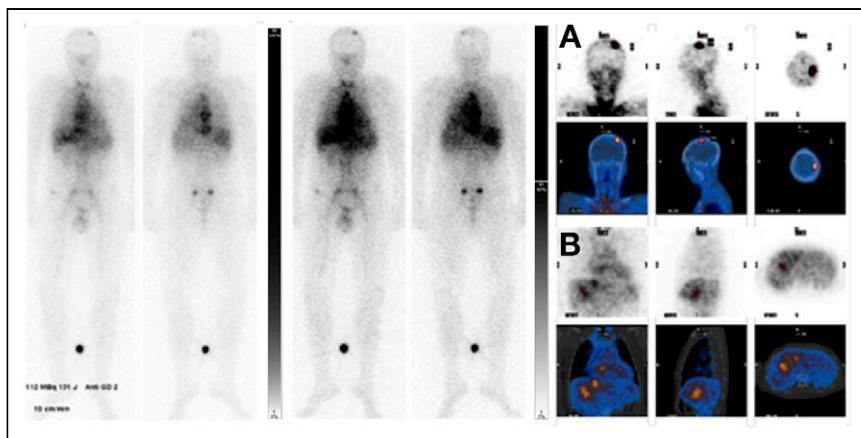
^{131}I -GD2-ch14.18 scan (left) with additional SPECT/CT on day 2 from application demonstrates intense targeting of bone (A) and liver (B) tumor lesions in patient 1, with neuroblastoma.
